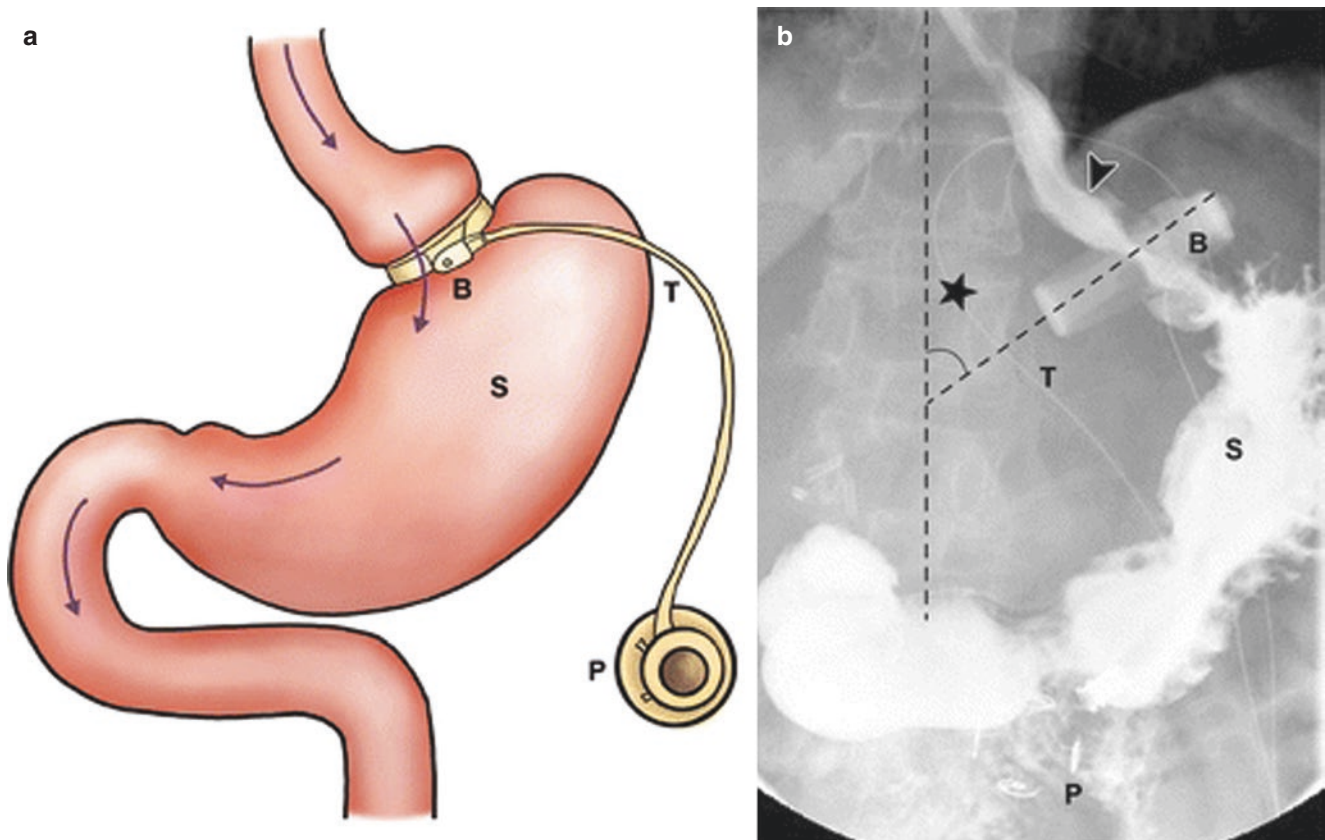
The phi angle can be used to determine band slippage. (a) Normal adjustable gastric band placement. (b) This demonstrates a normal phi angle of between 4–58° on xray. Abnormal is greater than 58°. (From Gaetke-Udager et al. [15])
